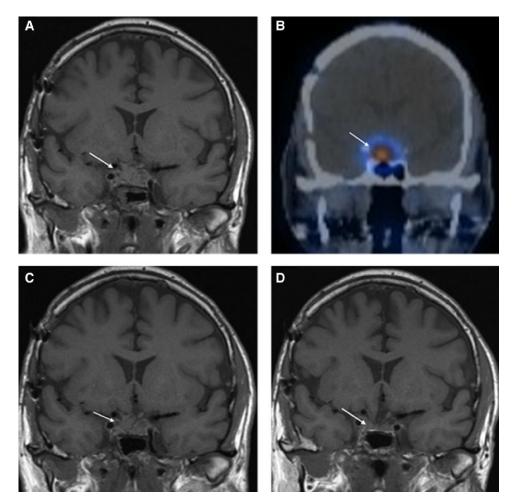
(A) Coronal MR T1 image of sella after 1 year of octreotide long-acting repeatable 20 mg intramuscular every 4 weeks showing persistent sellar lesion (arrow). (B) Indium-111 octreotide single photon emission computed tomography demonstrating moderate uptake in the sellar lesion. (C) MR sella after 4 treatment cycles of ¹⁷⁷Lu-DOTATATE showing no significant tumor shrinkage. (D) MR sella after 8 maintenance cycles of ¹⁷⁷Lu-DOTATATE showing partial tumor response.
